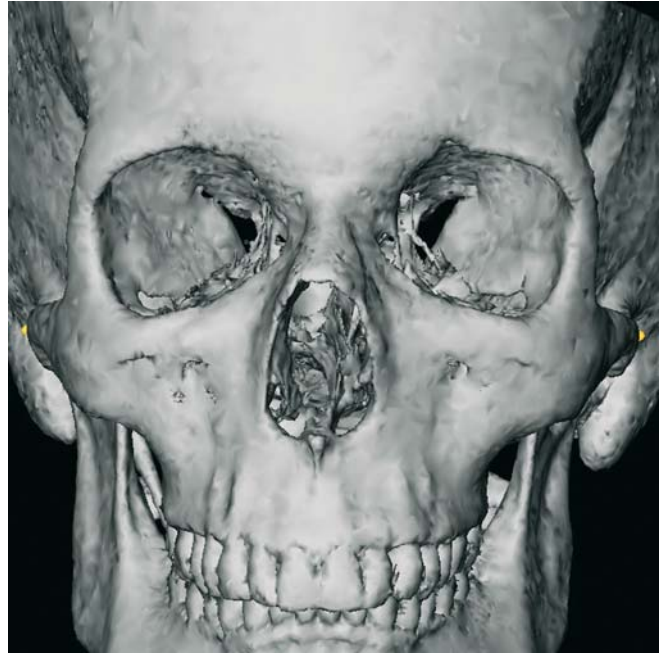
Zygion_r and Zygion_l, Frontal view (3-D CT, patient K.C.)
